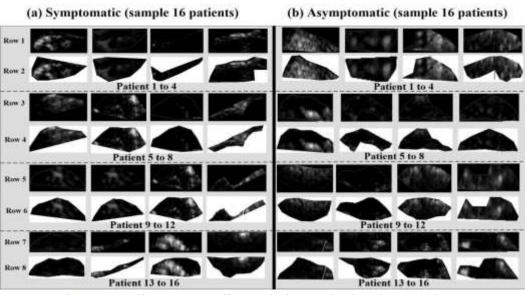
Full scan vs. Delineated plaques in the ultrasound.
